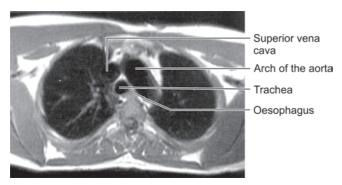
Cross sectional (axial) CT view of the thorax at the level of sternal angle
